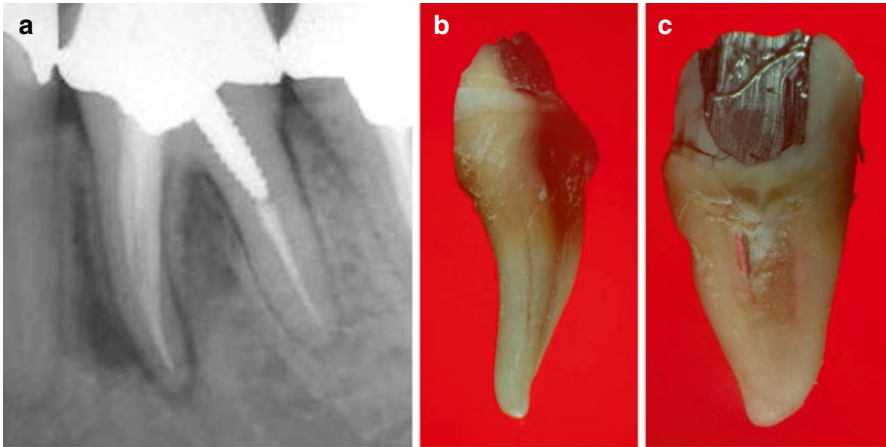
A periapical radiograph of endodontically treated mandibular molar. (a) Due to excessive removal of the root dentin, both a VRF (b) and strip perforation (c) had occurred
